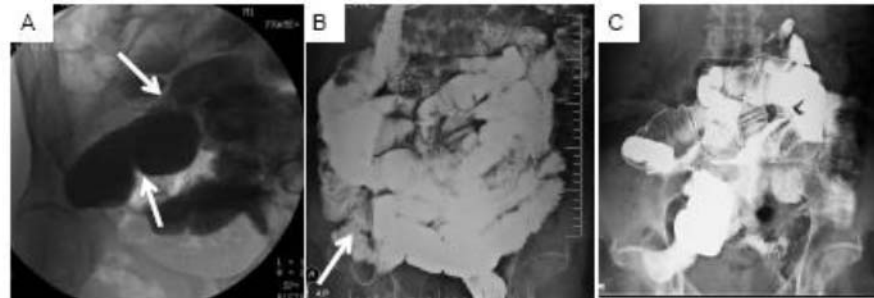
Small bowel radiographs of Patient 1 documenting SBO resolution over time. Arrows note areas of obstruction. (A) Before therapy in 2011: incomplete SBO due to adhesions visualized by X-ray showing dilation of the proximal mid ileum. (B) Twelve months after therapy in 2012: mild stricture at the terminal ileum with no other small bowel abnormalities. (C) After 40 h of therapy: normal small bowel series X-ray in 2012. Reprinted from J. Clin. Med. 2013, 2, 1-12; under a Creative Commons Attribution 4.0 International license.
